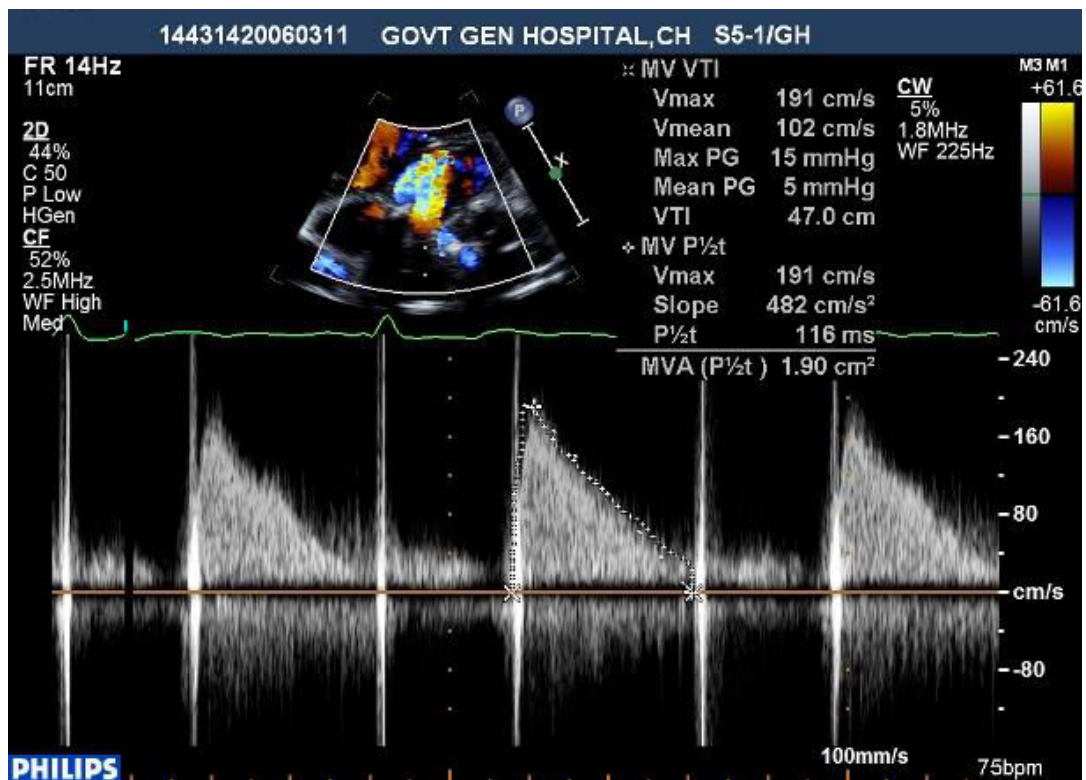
Figures showing echocardiography of opening of mitral prosthetic leaflet following successful thrombolysis
